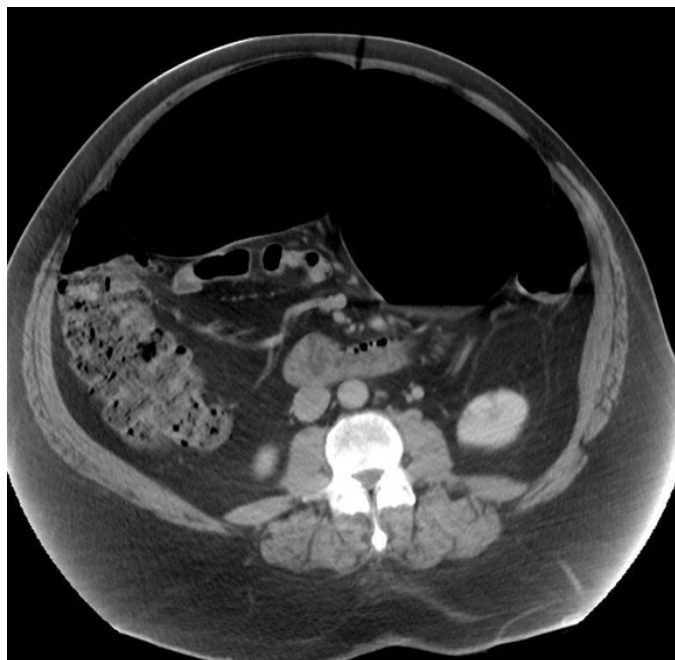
Case 1. CT scan showing dilated colon and sigmoid.
